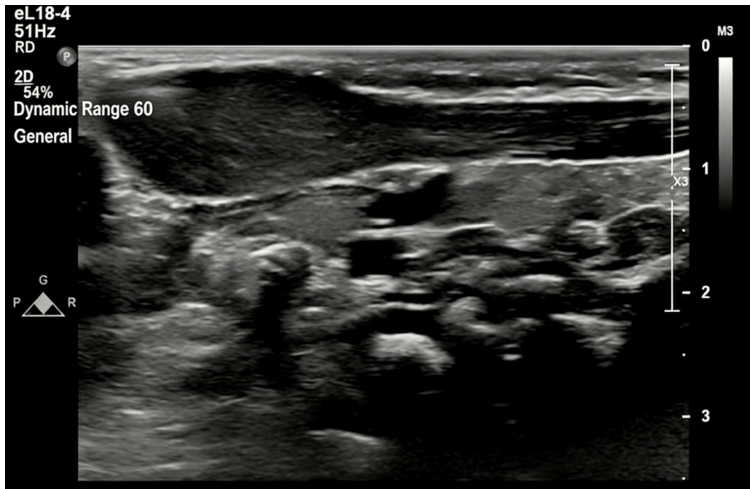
Typical preoperative longitudinal ultrasound image of the affected sternocleidomastoid muscle in a pediatric patient with congenital muscular torticollis, showing characteristic pathological changes including muscle thickening and increased echo intensity suggestive of interstitial fibrosis. Imaging was performed using a GE Voluson E8 system with a 7-18 MHz high-frequency linear probe.
